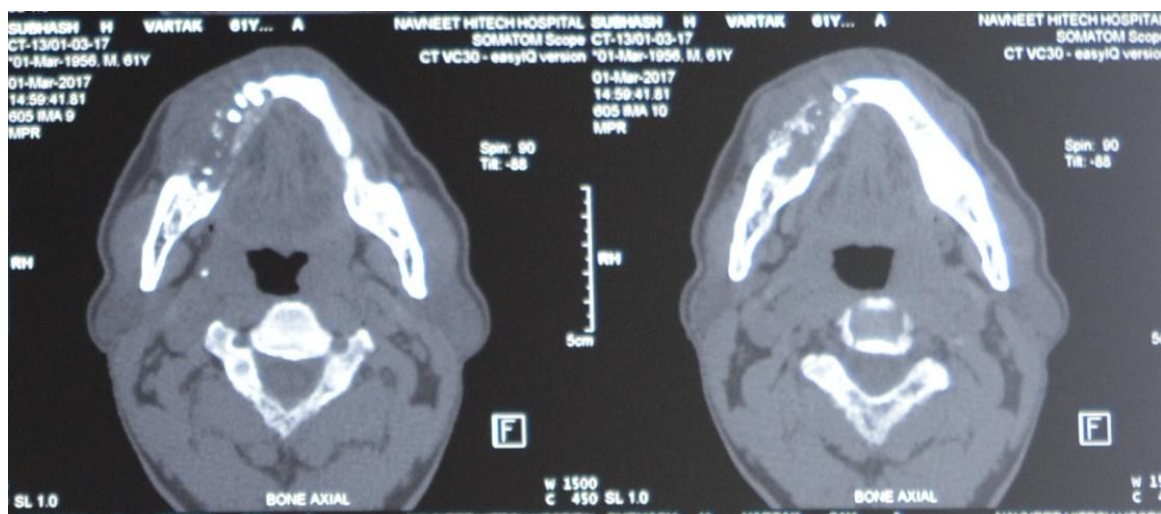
CT Scan- Axial section showing destruction of the buccal and lingual cortical plates in the right side body and parasymphysis of the mandible.
